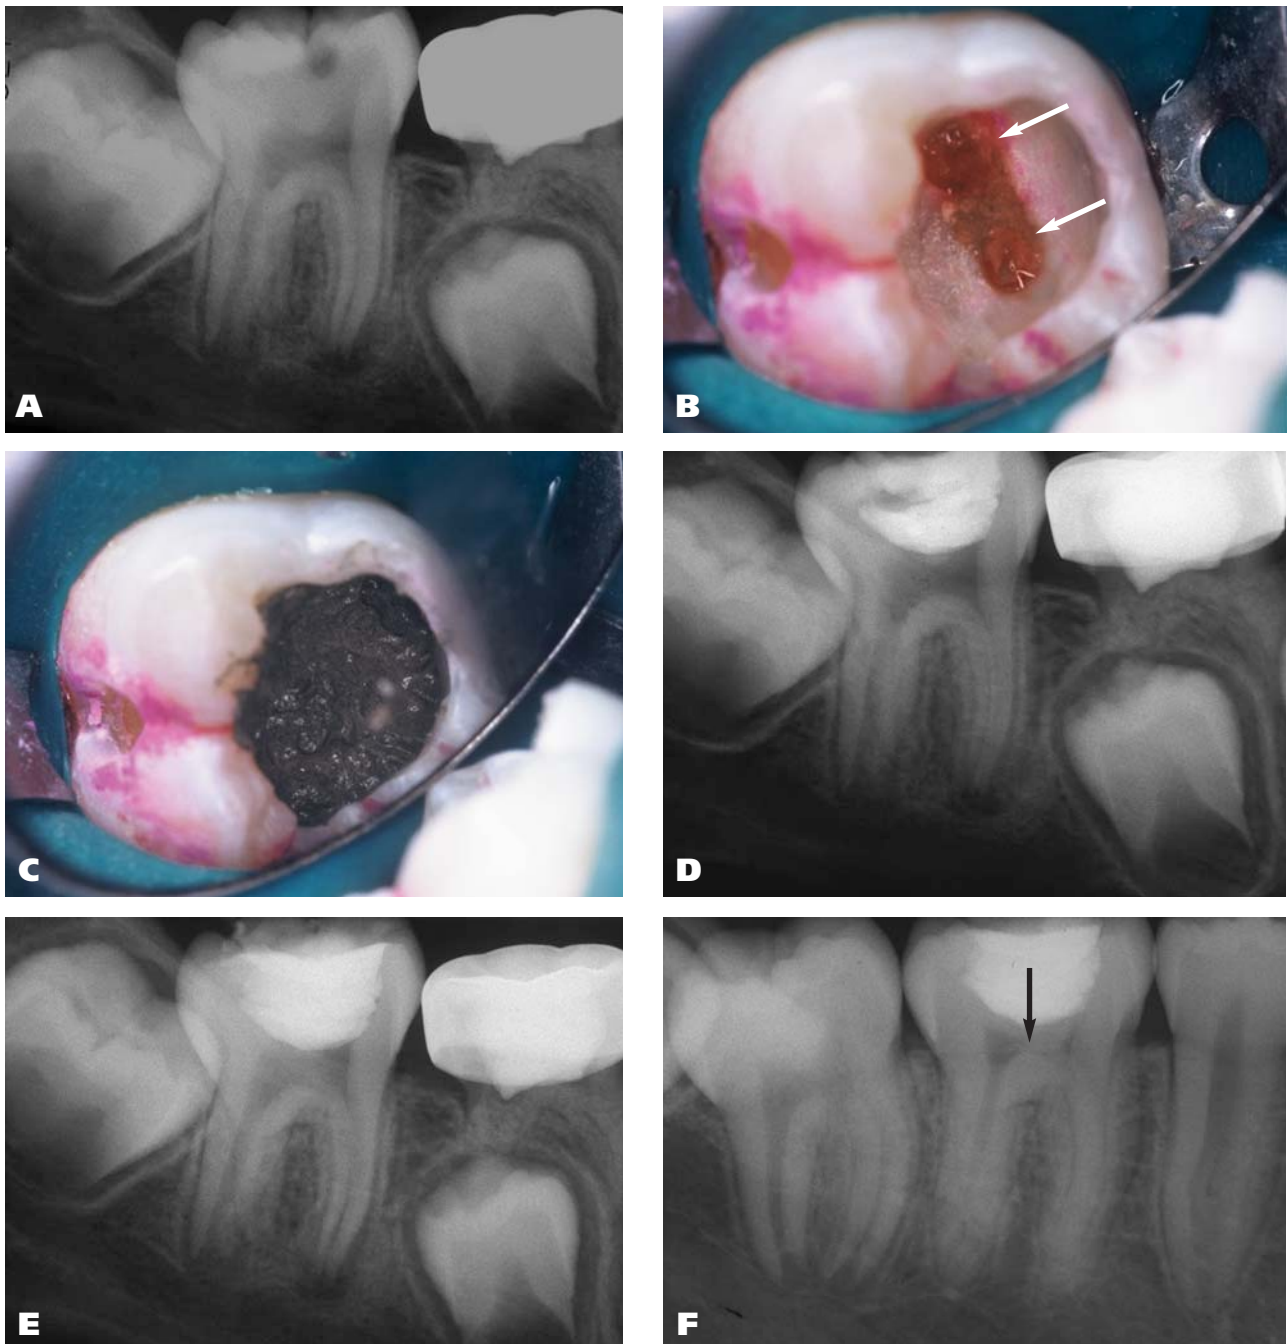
Treatment sequence of molar that was symptomatic on presentation in a 7-year-old boy. A. Pretreatment radiograph showing open apices and deep caries. B. Arrows showing two large 2.0- to 2.5-millimeter pulp exposures after caries excavation and hemostasis. C. Gray mineral trioxide aggregate placed over the entire pulpal roof. D. Radiograph after provisionalization. E. Molar after permanent restoration placement. F. Radiograph taken at the four-year, nine-month recall appointment showing extensive reparative bridge formation (arrow). Cold stimulus testing revealed a normal pulpal response.
